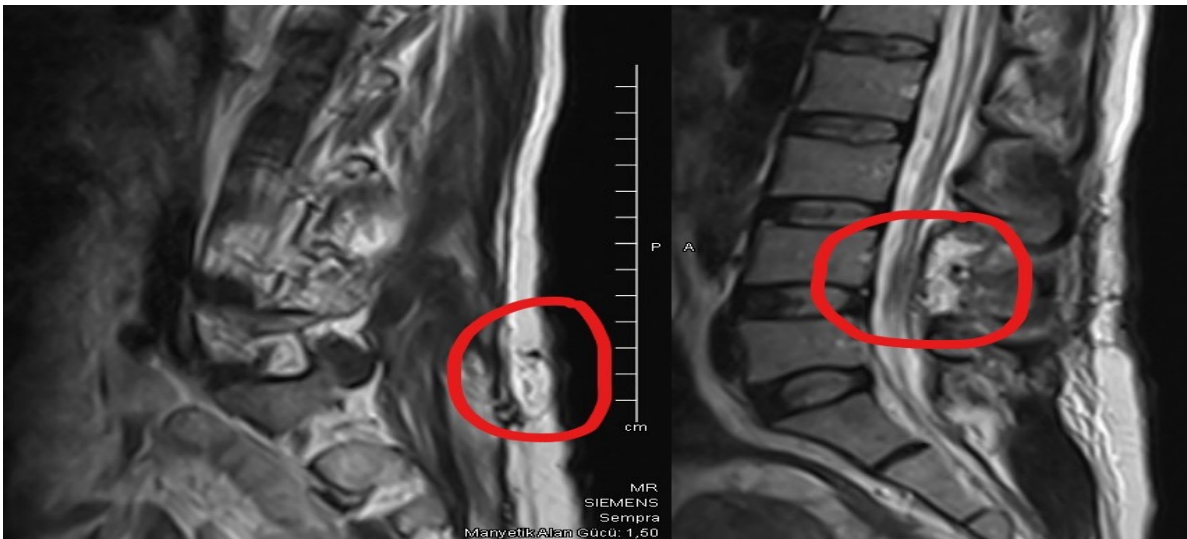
Post-op period (area marked with red ring): Post-op MRI examination shows that the subcutaneous hydatid cyst lesion and spinal tumor have been completely excised.)
